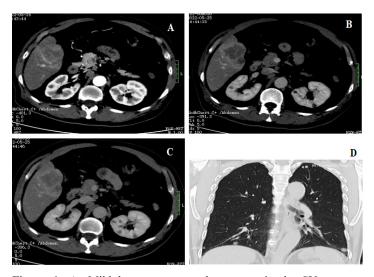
A: Mild heterogeneous enhancement in the SV segment of the liver in the CT arterial phase; B-C: Continuous and noticeable enhancement in the edge of the CT portal vein phase and delayed phase; D: Multiple metastases in both lungs.
